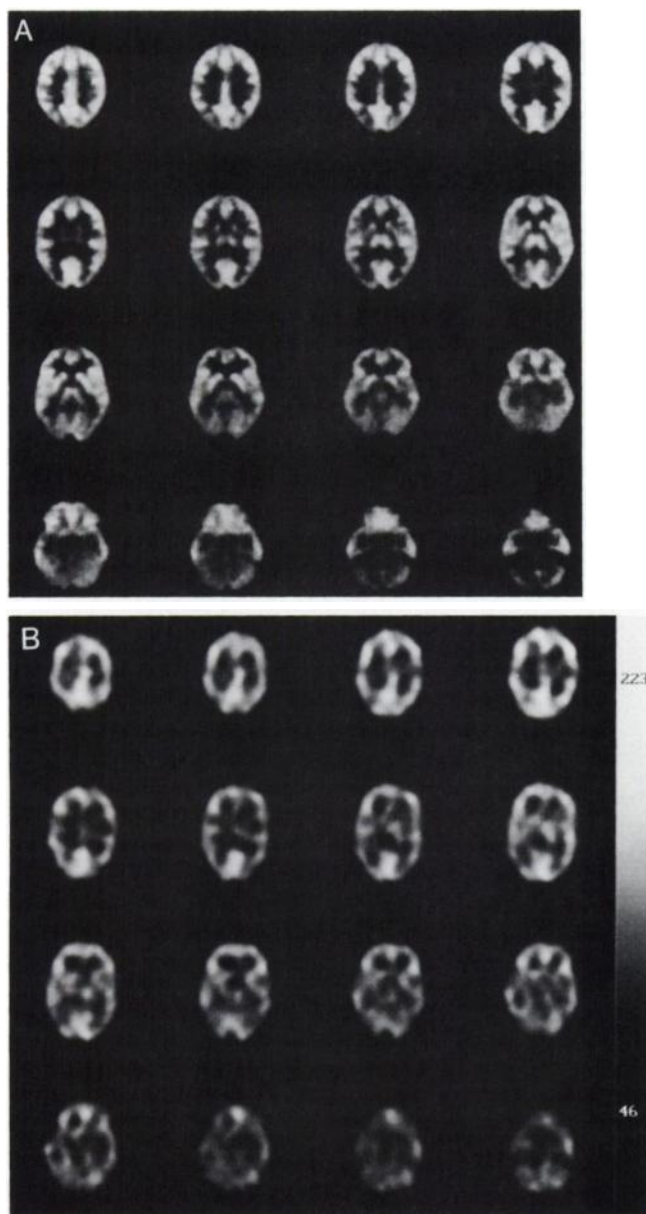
Typical ^{18}F FDG brain scan without lesions in the field of view. (A) ^{18}F FDG-PET and (B) ^{18}F FDG-SPECT.
